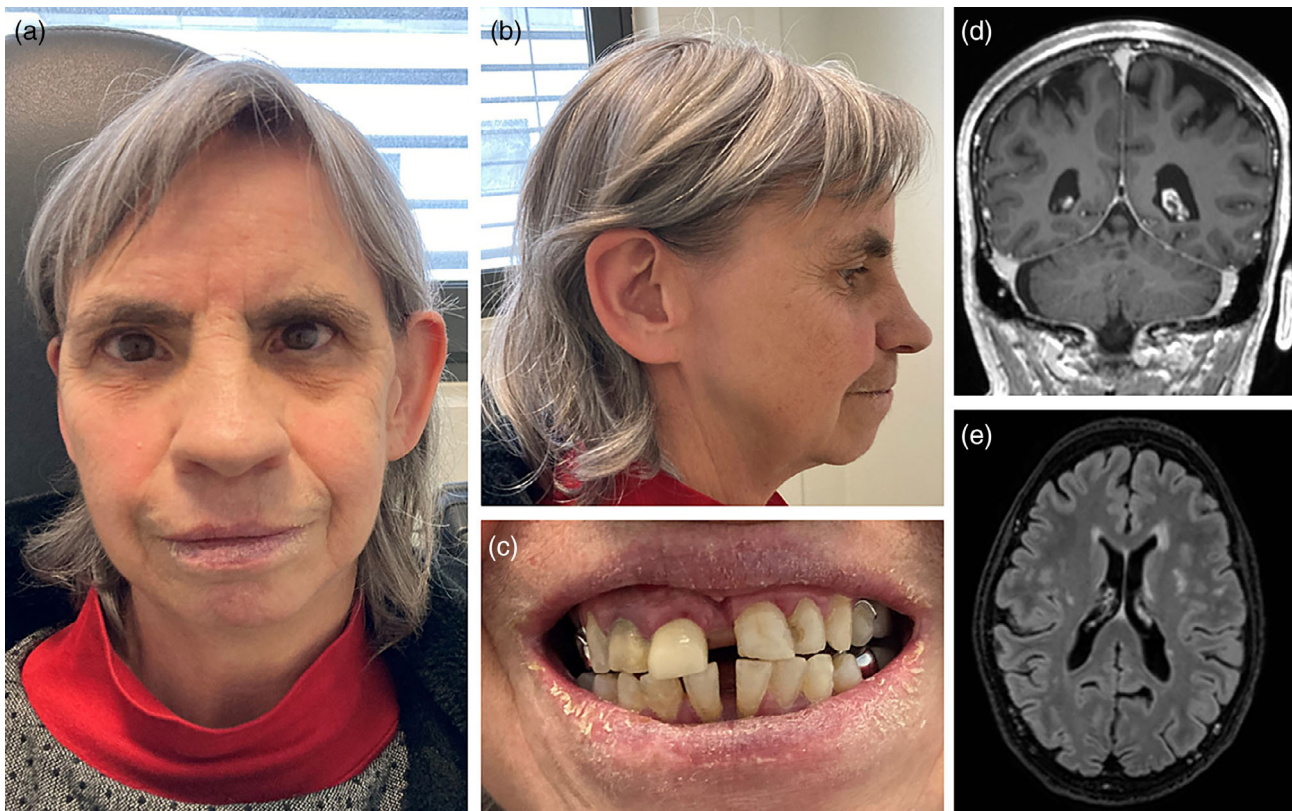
Extra-ocular features observed in the 68-year-old patient with a heterozygous *ITPR1* pathogenic variant. (a–c) Photographs showing miosis and craniofacial dysmorphism with diastema between maxillary central incisors. (d–e) Cerebral MRI. (d) Contrast-enhanced coronal T1-weighted image showing normal volume of the brain and cerebellum. (e) Axial FLAIR image revealing only mild non-specific white matter hyperintensities.
